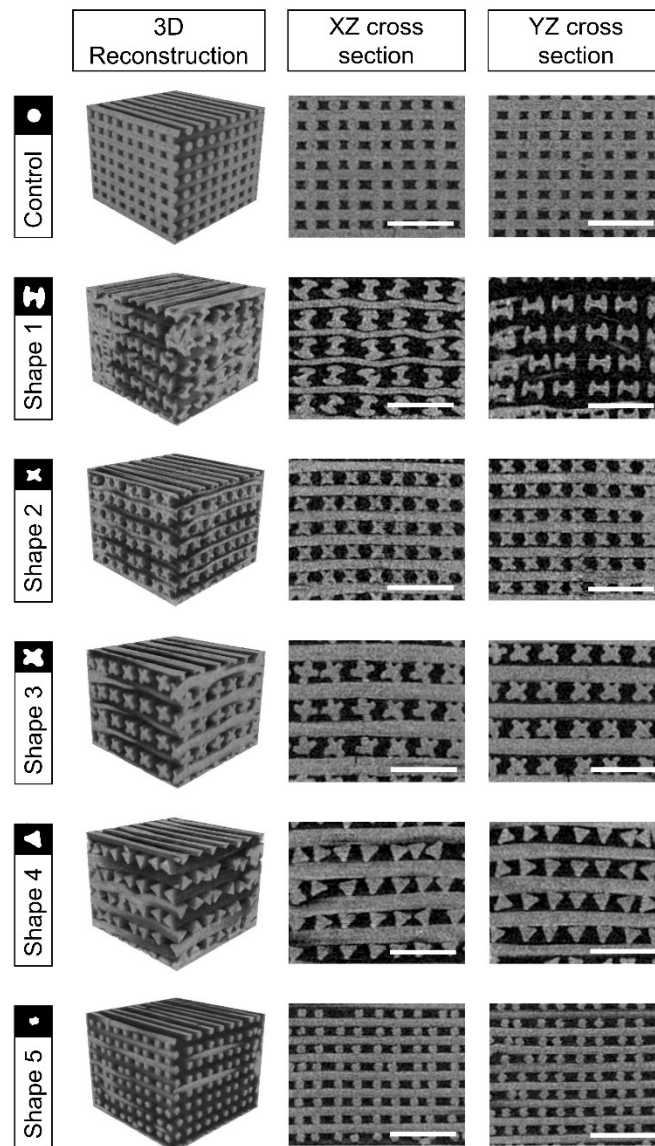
3D reconstruction and XZ and YZ cross-sections of the μ -CT images of the 3D structures printed with the different nozzle geometries. Scale bar: 2 mm.
